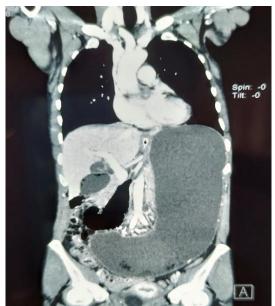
CT scan images showing hugely distended stomach filled with content
